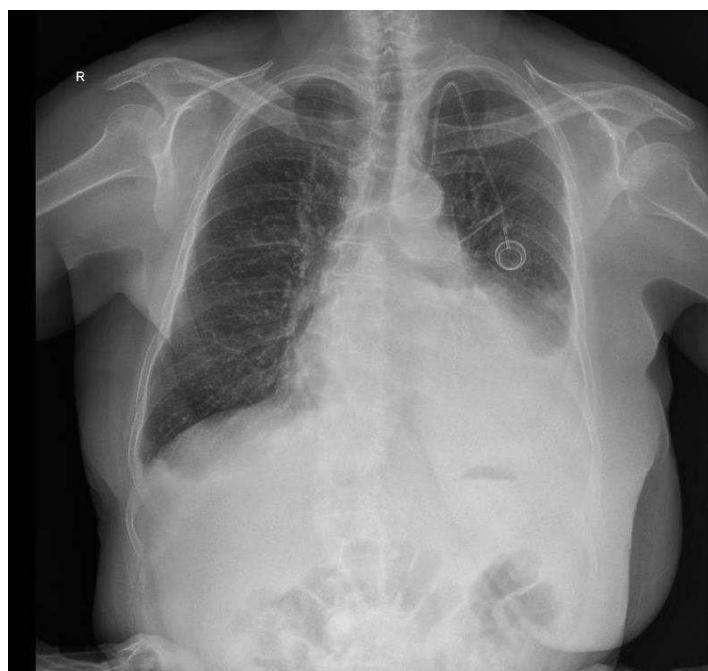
Control chest X-ray
